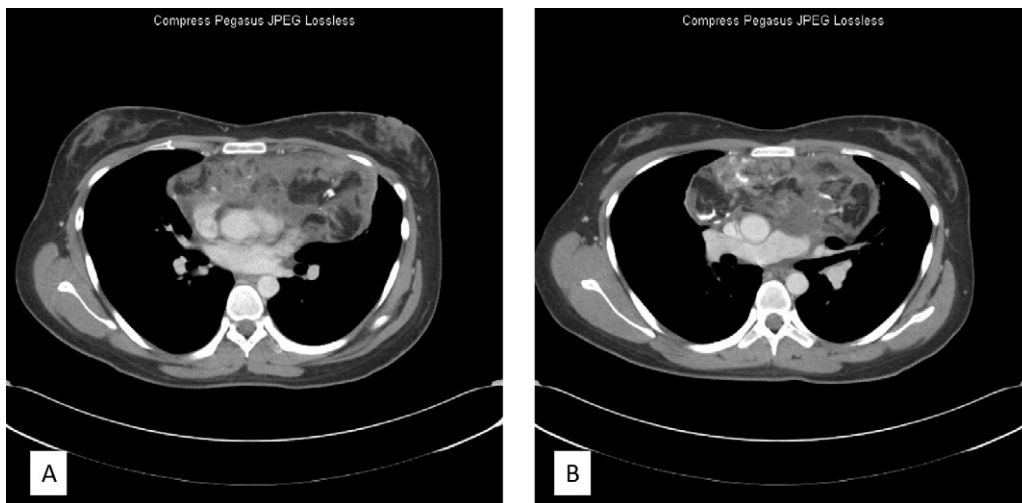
Mediastinal mass on sagittal view on CT scan: with appearance of invasion of the left pulmonary vein (A) the aorta and the left pulmonary artery (B).
